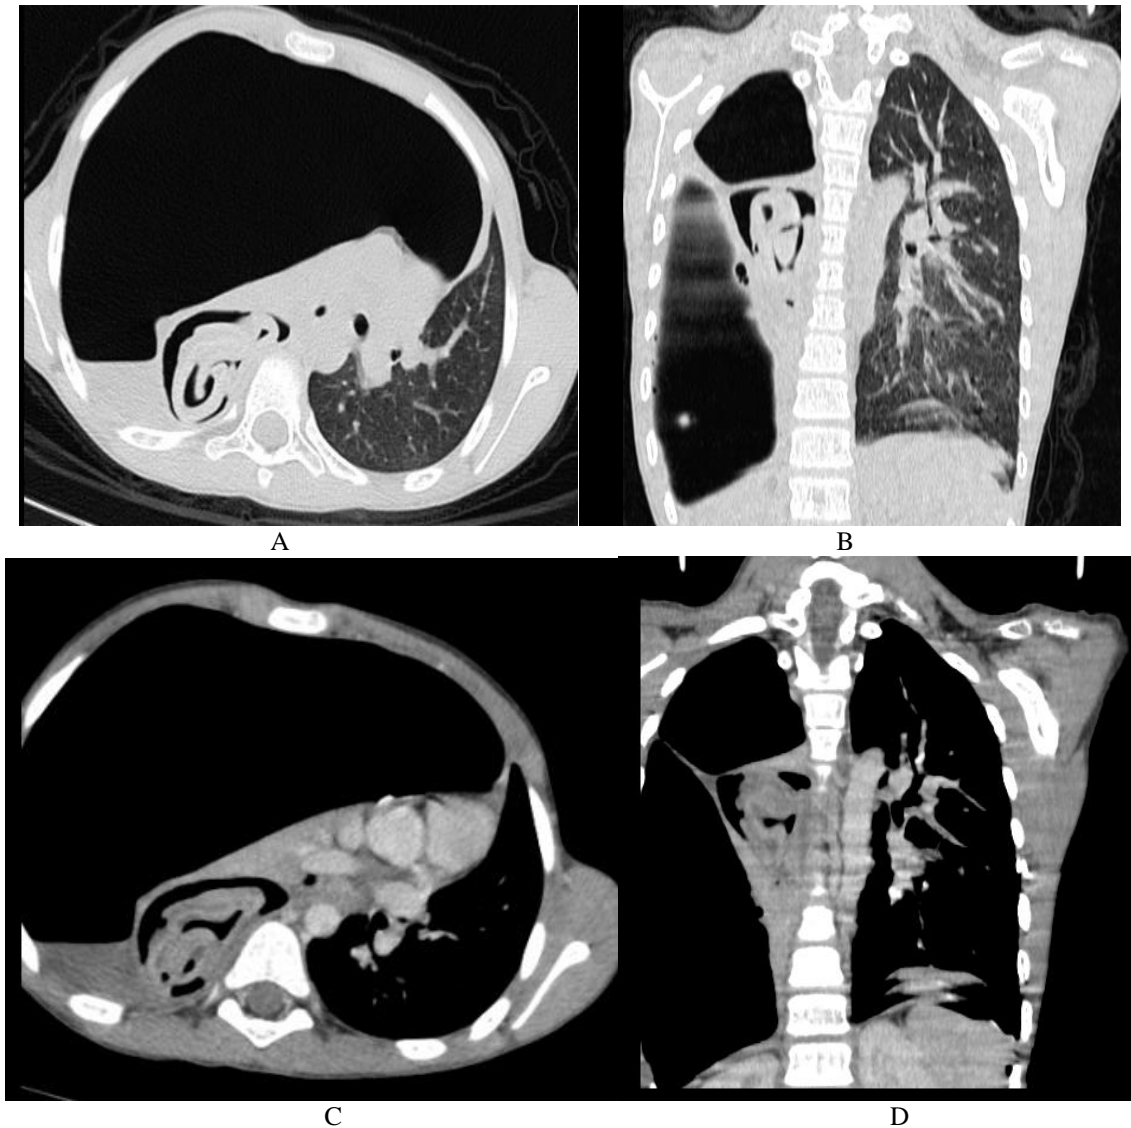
Chest CT scan after PDC injection, parenchymal window in axial and coronal sections (A and B); mediastinal window in axial and coronal sections (C and D): large compressive right hydropneumothorax with cavitary image of the pulmonary stump containing membranes
